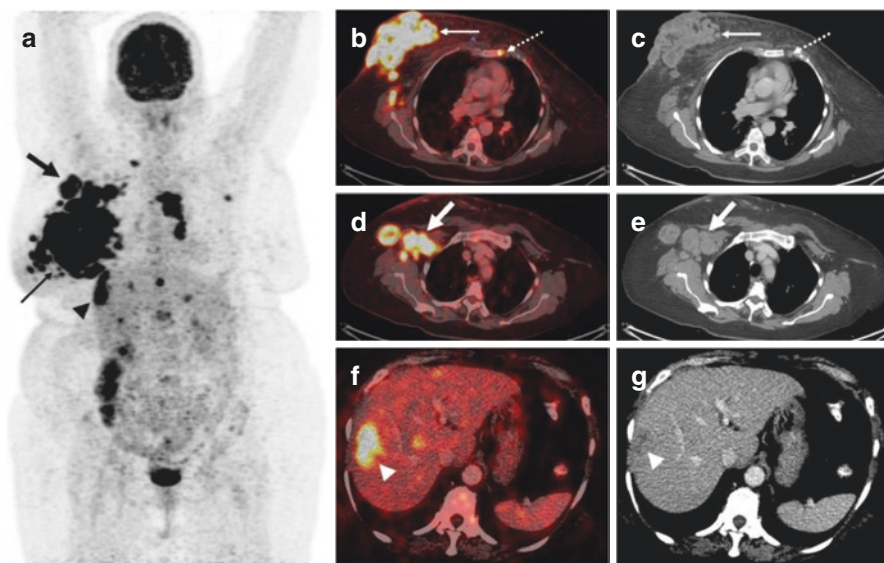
A 57 year-old-woman with newly diagnosed carcinoma right breast (Inflammatory breast carcinoma) underwent ^{18}F -FDG PET/CT for initial staging. Maximum intensity projection image (a) and trans-axial fused PET/CT and CT images show intensely tracer avid right breast mass, infiltrating the skin (b, c; solid thin arrow), multiple enlarged, matted right axillary lymph nodes (d, e; solid thick arrow) and tracer avid hypodense liver lesions (f, g; arrow-head) in addition to multiple skeletal lesions (representative sternal lesion shown in b, c; dotted arrow)
